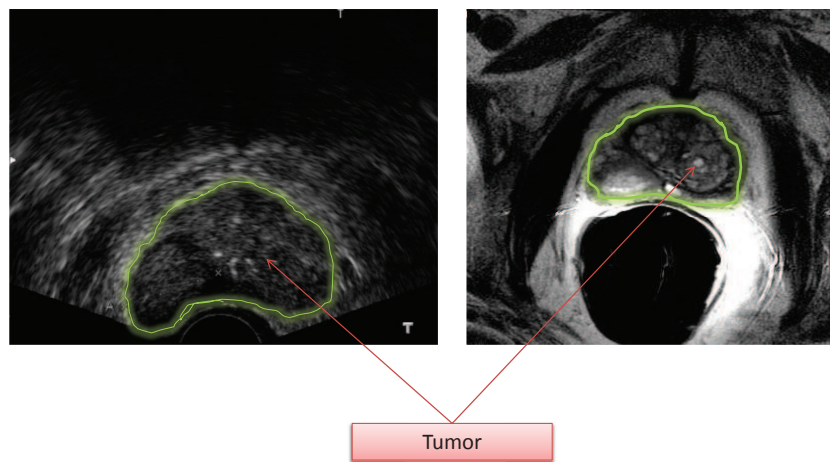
Prostate in TRUS and MRI. Better soft tissue contrast in MRI aids in visualization of a tumor that is not visible in TRUS images.
